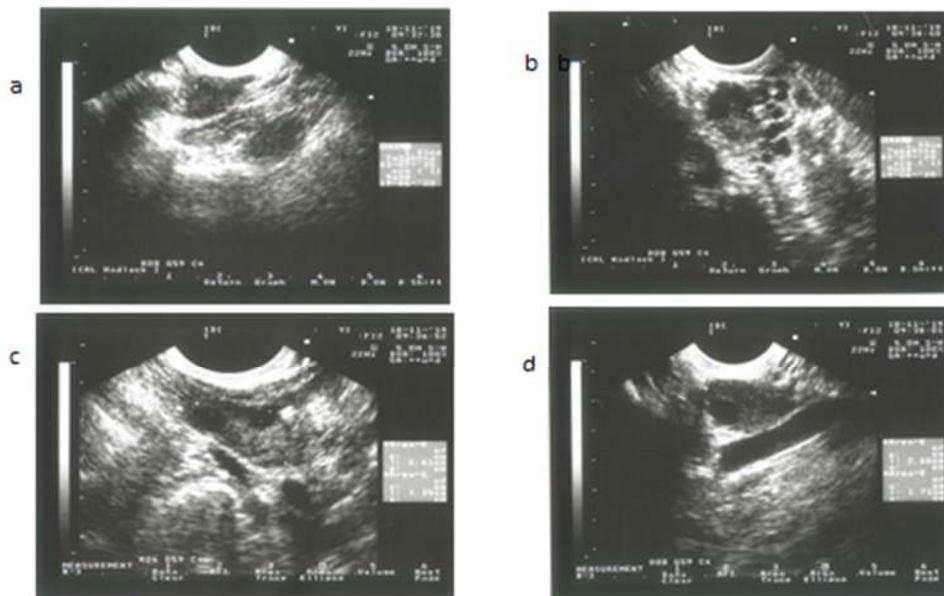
ultrasound images for OD-C female. a and b showed right ovary with measurement about 2.61X1.35 cm. b and d for the left ovary, which is 1.35X2.66cm .
